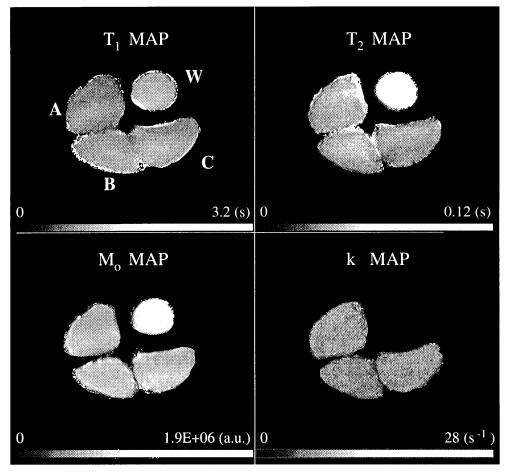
T_1 , T_2 , M_0 and k (MT rate) images (256 × 128 pixels) of a 0.1 mm MnCl₂ aqueous solution (W) and three sub-samples of pork (A, B and C) which are the frozen/stored/thawed pork samples of Experiment II. The average of the values for each area of each sub-sample is used to produce the MRI result for T_1 , T_2 and k.
